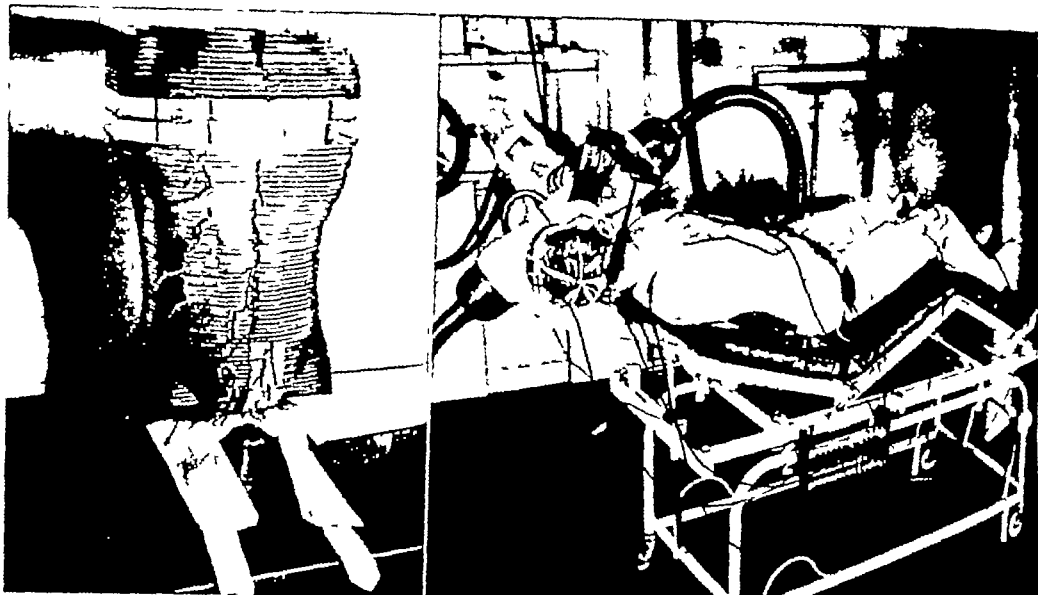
A (left) Method of construction of celluloid man B (right) Complete celluloid man having x-ray "treatment" (Boag, 3)
